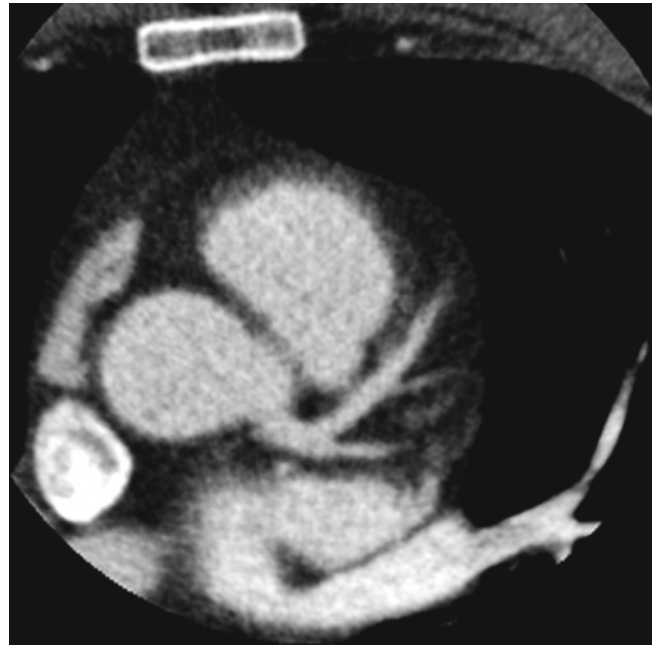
Electron beam CT. The electron beam CT (EBCT) scanner was designed to provide sufficient temporal resolution for cardiac imaging. To avoid rotation of an X-ray tube, an electron beam was created by an electron gun inside a very large vacuum tube. The electron beam was focused and deflected by electronic coils to rapidly sweep across stationary, semicircular targets that were arranged below and around the patient. Where the electron beam hit the targets, X-rays were
